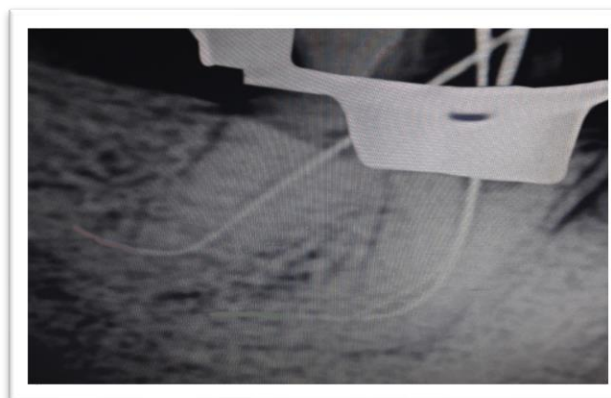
b: Working length radiograph
